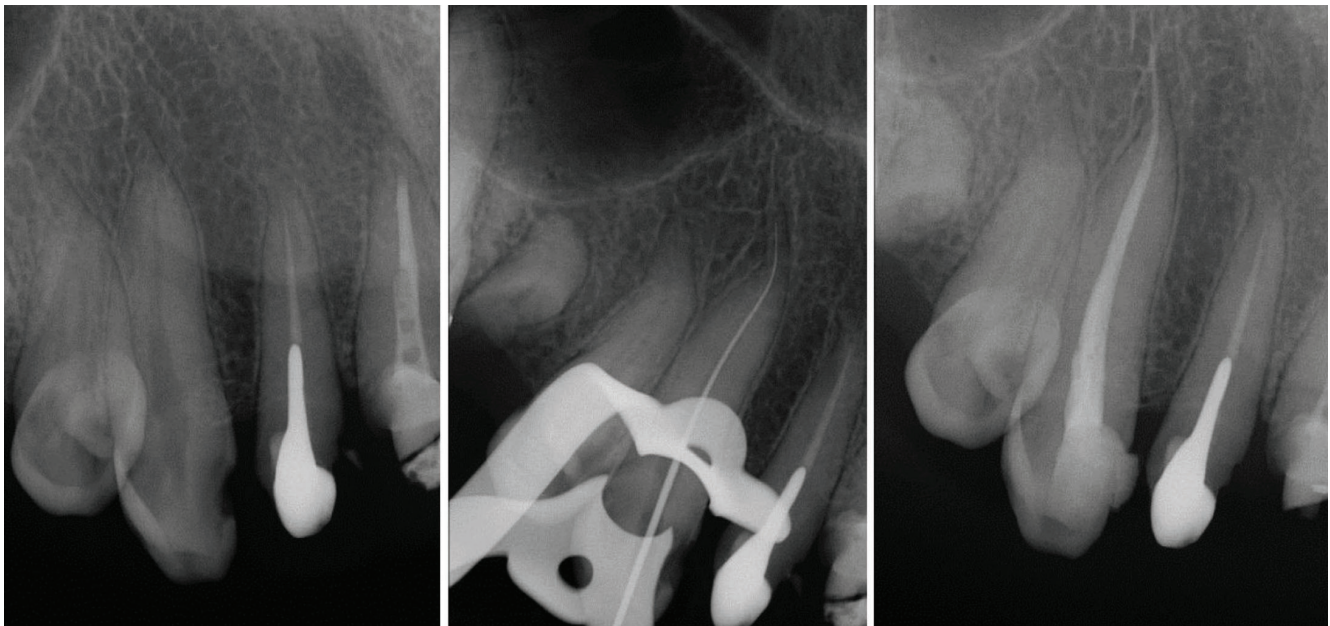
Preoperative radiograph. Figure-2: Working length determination. Figure-3: Postoperative radiograph.
